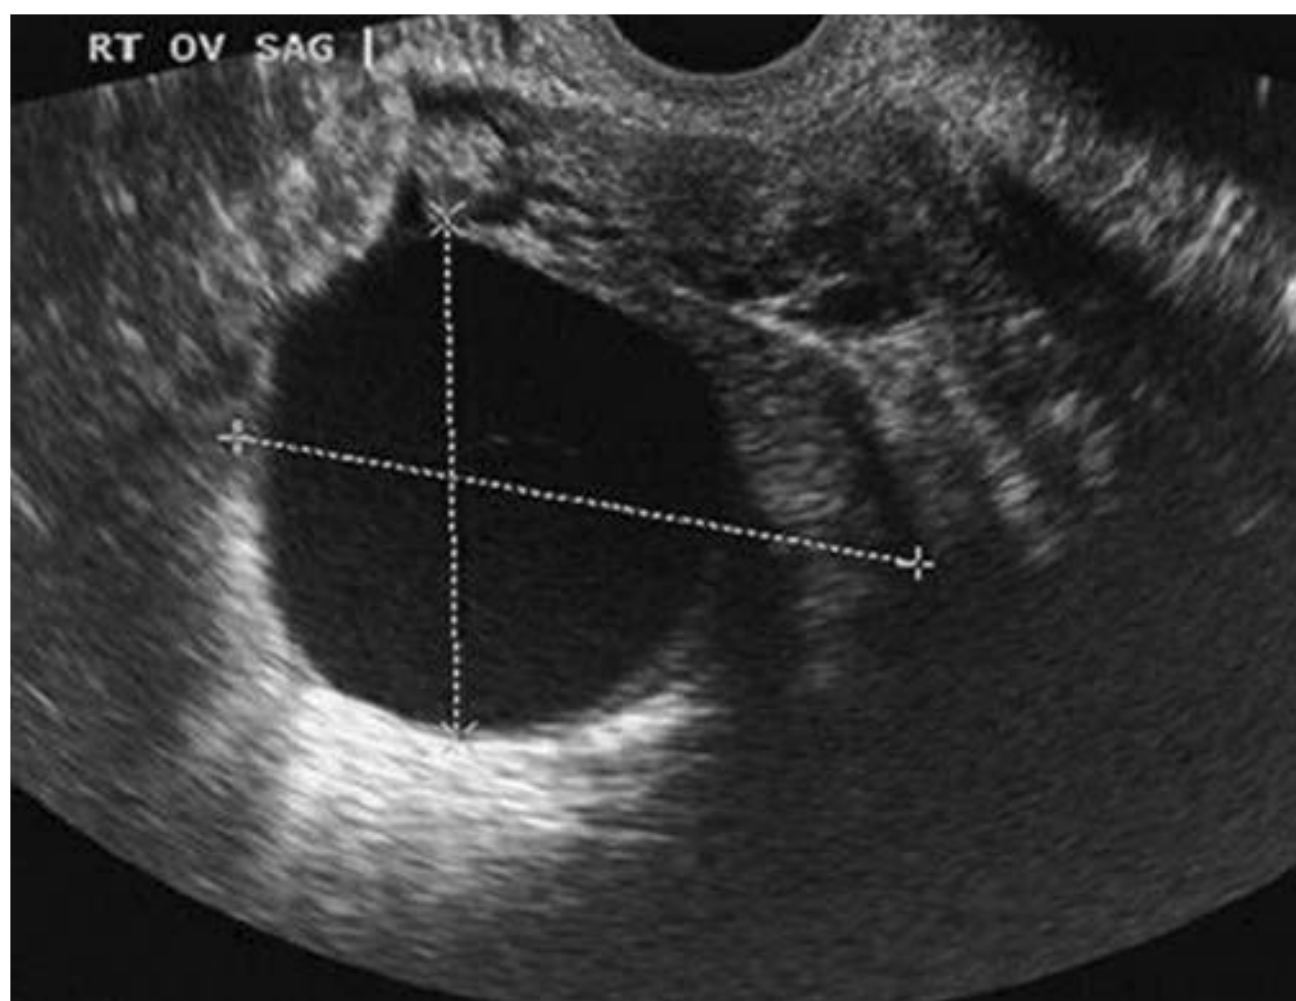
Transvaginal sonogram of a premenopausal ovary containing a follicular cyst. The cyst fluid appears black or anechoic. Note the white or hyperechoic area under the cyst, a sonographic feature called posterior acoustic enhancement or through transmission.
